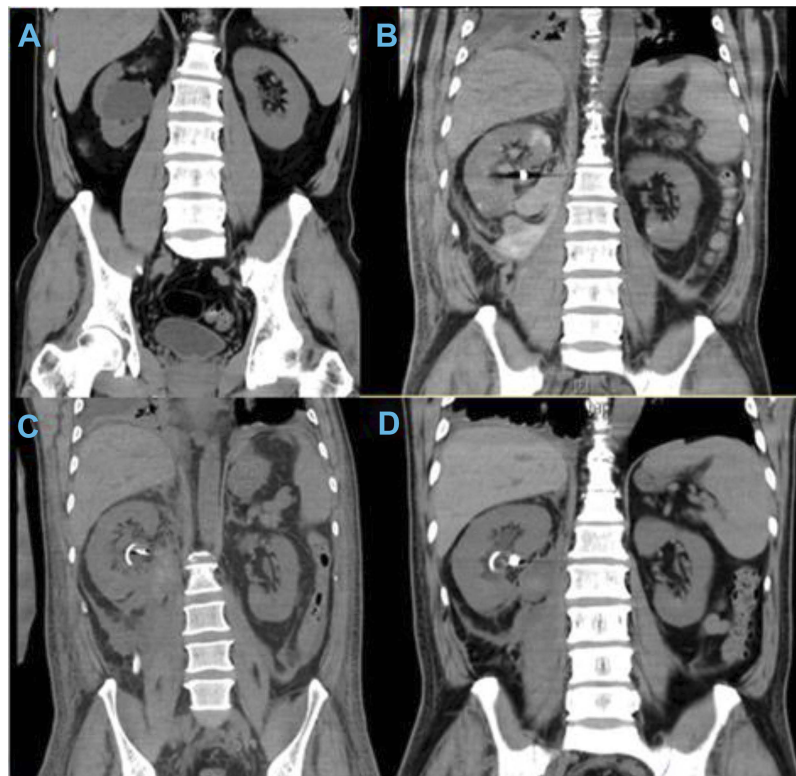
(A) An elliptical cyst located in middle and low pole of the right kidney, which had low density with clear border and no enhancement, had been found. The size of the cyst was about $36 \times 51 \times 37$ mm. And there was also an adrenal nodular hyperplasia with the diameter of 5 mm presented in the left adrenal. The left renal pelvis was compressed, and the left kidney was normal in size and position, with regular morphology and no abnormal density in renal parenchyma. Bilateral ureters showed no dilatation and abnormal density shadow. (B) At POD4, compared with the previous CT image, DJ tube could be seen in the right urinary tract, and high-density artifacts were seen in the right sinus. The shape of the right kidney was irregular and the density was not uniform. There were multiple wedge-shaped high-density shadows, and exudation and high-density shadows were seen around the right kidney and behind the peritoneum. The maximum cross section was about 104×72 mm. The middle and lower pole of the right kidney showed elliptical cystic low density, which was slightly smaller than the former, and the size was about 4.5×2.6 cm. The size and shape of the left kidney can be seen. The left renal pelvis and ureter had no obvious dilatation or abnormal density shadow. (C) At POD 14, double-J tube could be seen. Drainage tube shadows were seen in the right retroperitoneal space. High-density artifacts can be seen in the right sinus. The morphology of the right kidney was irregular and the density of parenchyma was uneven. The cystic density in front of the right iliac psoas was obviously lower compared with before. A small amount of fluid in the abdomen and pelvis was presented. (D) At POD 27, high-density artifacts can be seen in the right sinus. The morphology of the right kidney was irregular and the density of parenchyma became more uniform. The size of the irregular cystic shadow in the anterior part of right iliopsoas muscle was smaller, and the density was lower than before. A smaller amount of effusion was seen in the abdominal cavity. And no clear effusion was found in the pelvic cavity.
